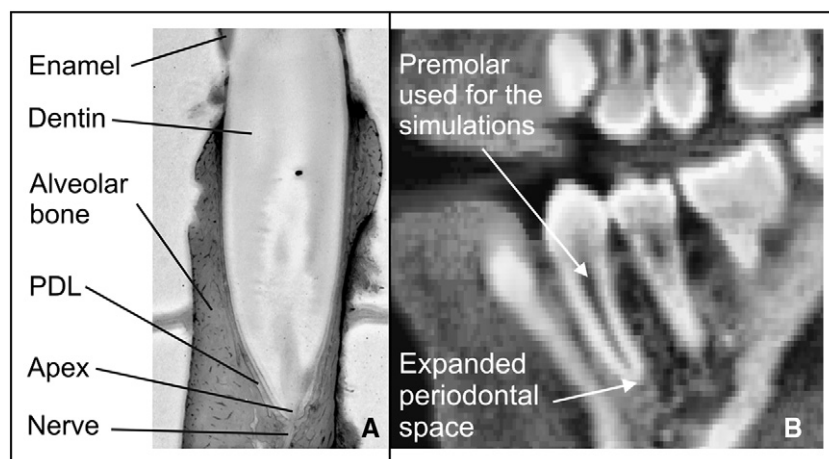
A, Dental anatomy; B, sagittal view of the CT data set used for model generation.
